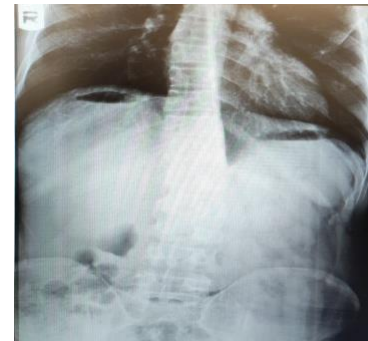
An x-ray with air-fluid level in RUQ
